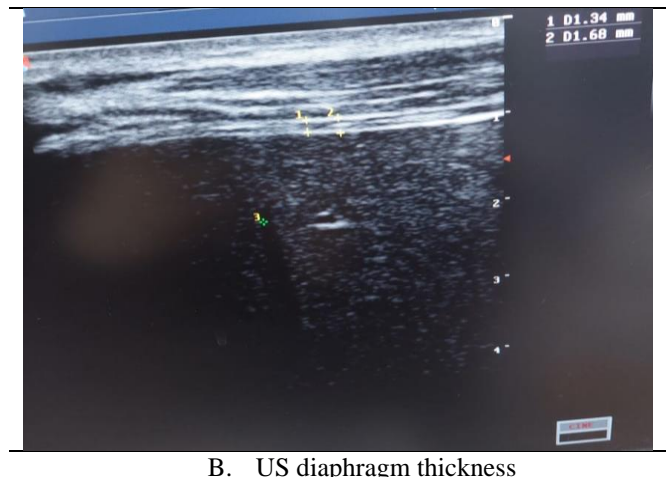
Sonographic assessment of diaphragm excursion
